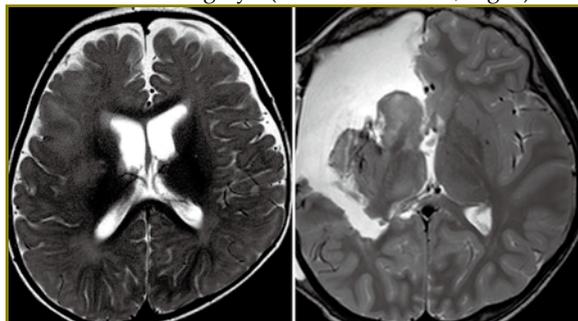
Right hemispheric FCD. Left panel: Pre-operative T2-weighted MRI image. Right panel: Post-operative MRI image after previous frontal lobectomy, and lastly right periinsular hemispherotomy. Source: From personal collection.
